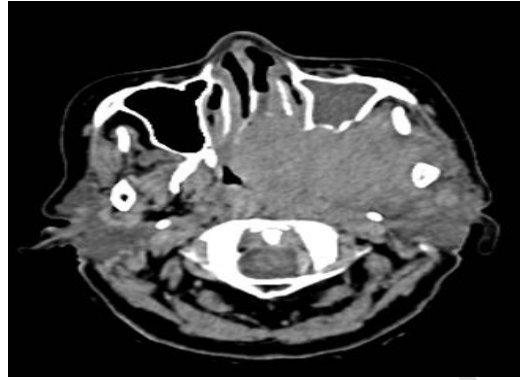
CT scan revealed mass originate from left nasopharynx
